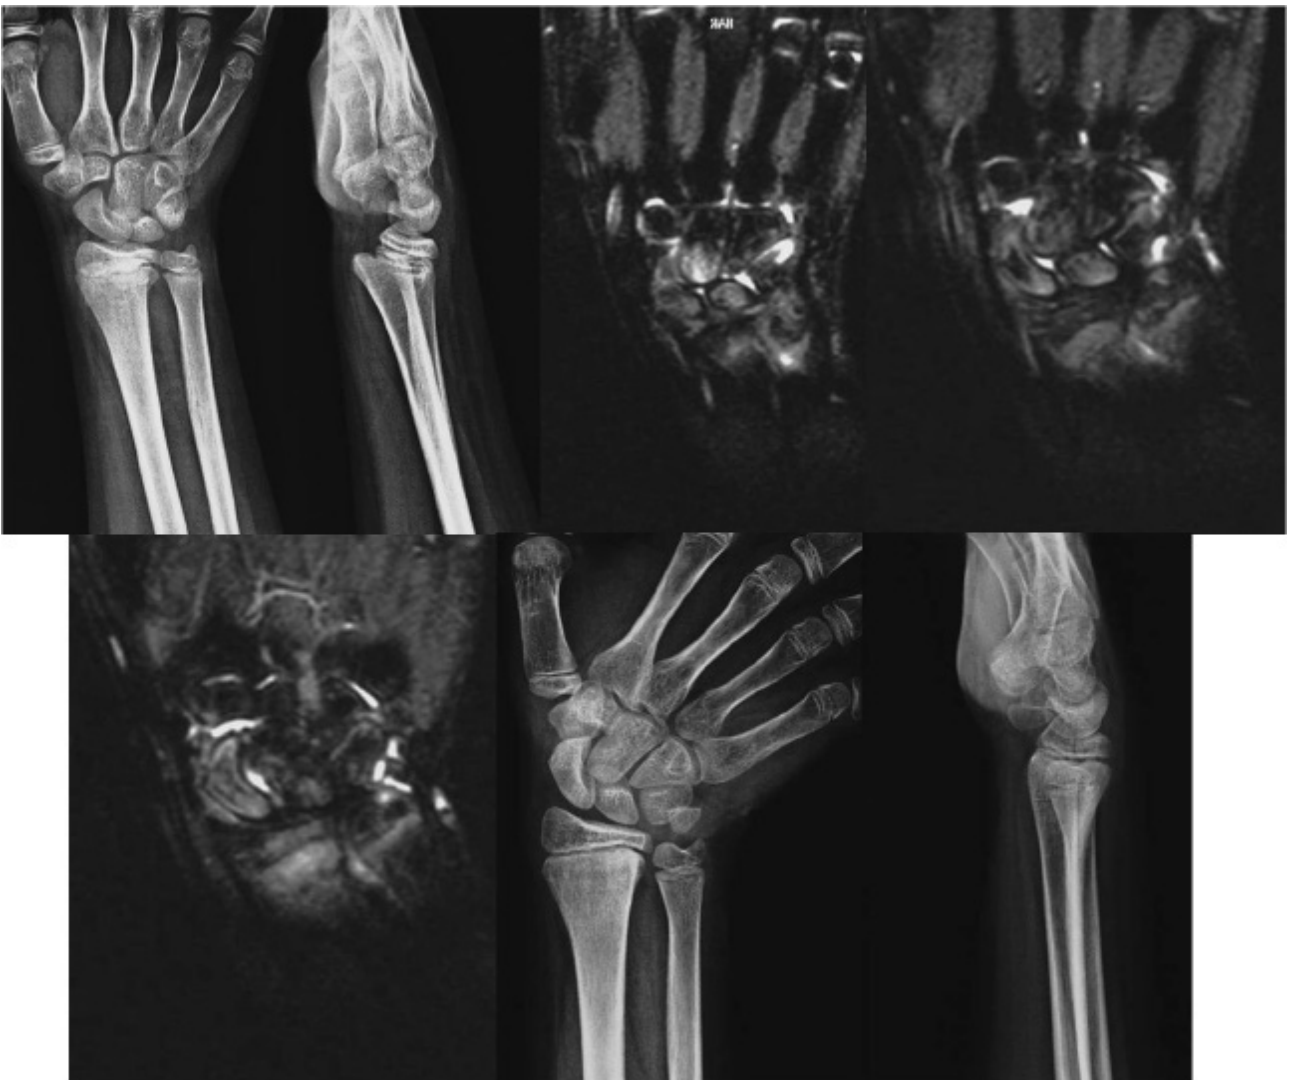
A 12-year-old boy was referred 2 weeks following a football injury (the ball forced the wrist into extension). The fracture was immobilized but reduction was not attempted. A MRI was performed due to radial-sided wrist pain, following cast removal, 5 weeks post-injury. Short tau inversion recovery images showed diffuse bone bruising of the carpal bones, including the scaphoid, with fluid signal between them. Further immobilization and protection was offered for a total period of 3 months post-injury. By that time the patient was symptom-free and radiographs indicated complete remodeling of the displaced fracture of the distal radius.
